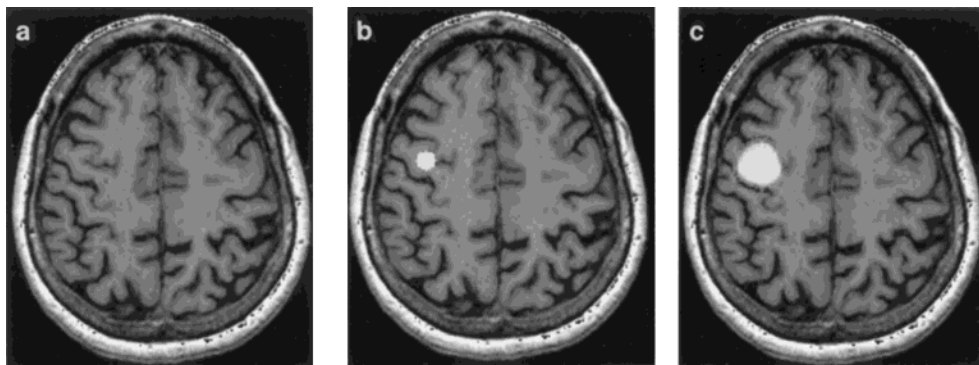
The use of prestrained elasticity in modeling tumor growth. (a) A cross-section from a volumetric MR image. (b) A cross-section from an initial (hypothetical) spherical tumor placed in (a). (c) A cross-section from the resulting expanded tumor.
